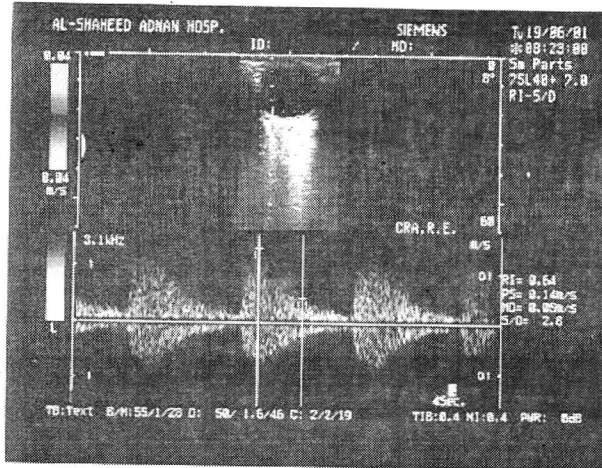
Central retinal artery (Normal pulsated Doppler waveform).
